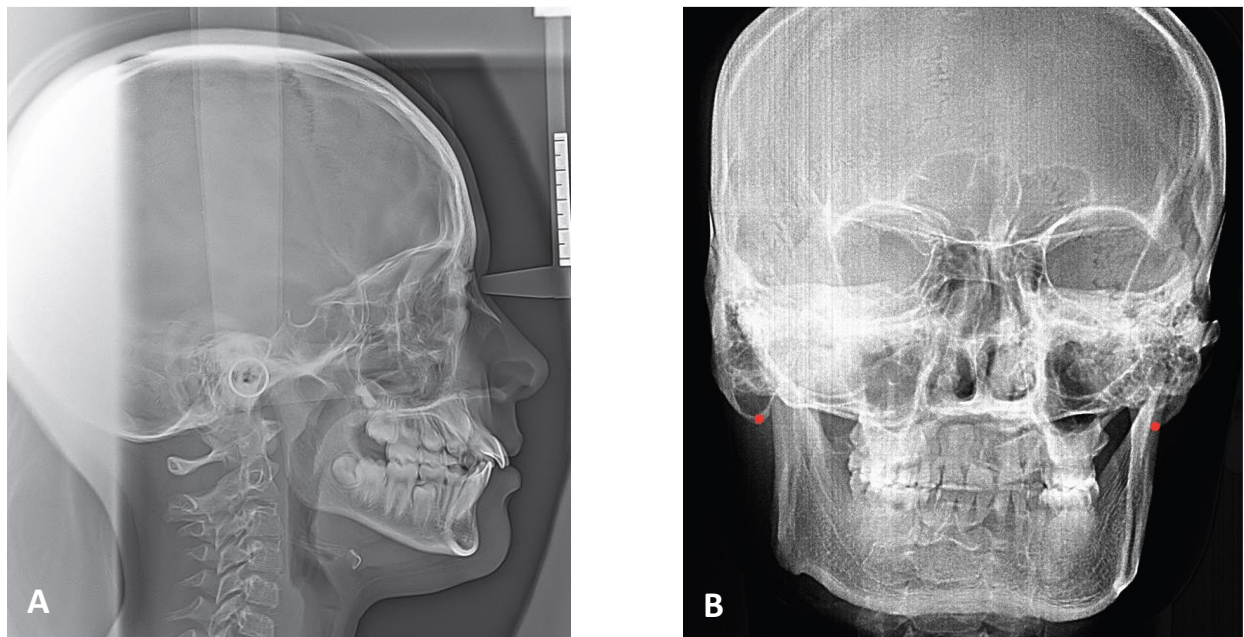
Cephalometric radiograph A- Lateral B- Frontal (Phulari, 2013).
